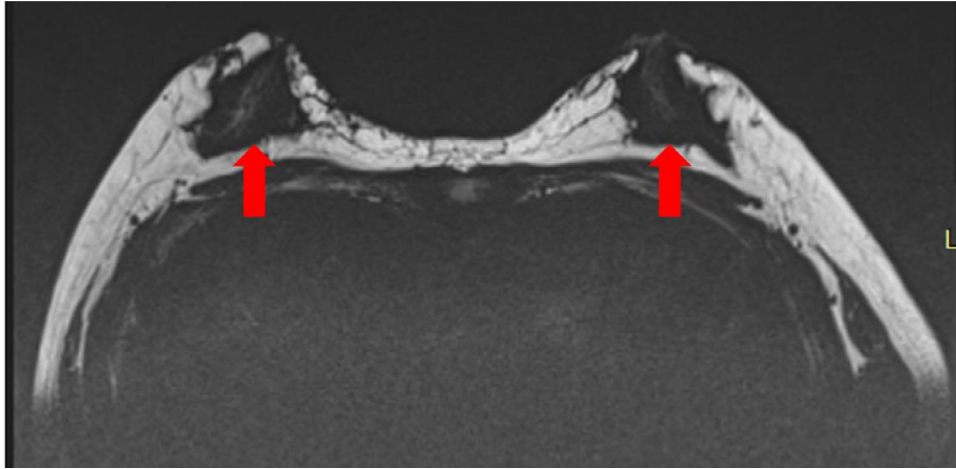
Axial silicone-suppressed T2-weighted image of both breasts showed failure to remove silicone signal. Water was suppressed instead of silicone because of the absence of silicone peak.
